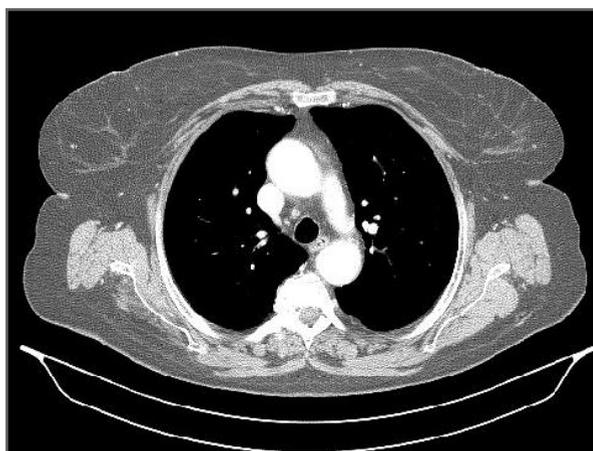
Toraco-abdominal and pelvic CT after treatment (resolution of breast and subcutaneous nodes)
